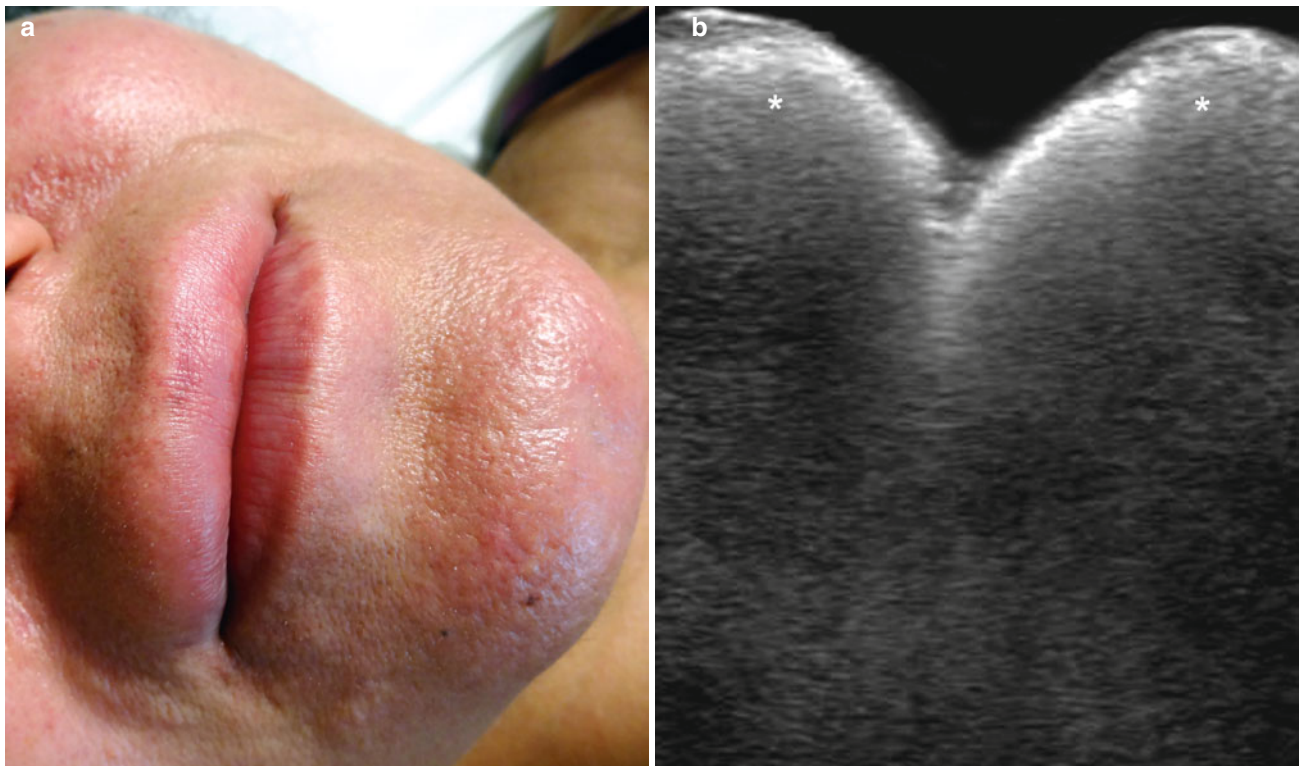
(a, b) Silicone oil complication. (a) Clinical image shows erythema and edema of the lips and chin region. (b) Grey scale ultrasound image (longitudinal view) demonstrates hyperechoic deposits (*) with a “snow storm” pattern affecting the upper and lower lip
